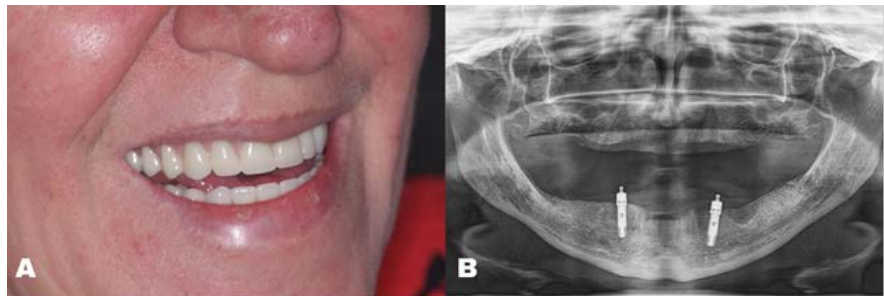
A, clinical control with 3 months, after rebasing of prostheses. B, panoramic radiography in the control at 3 months.
